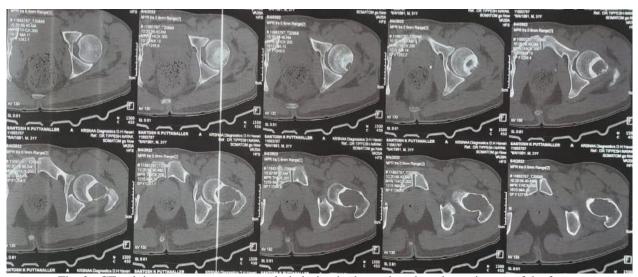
CT pelvis scan suggests an osteolytic lesion in the neck and trochanteric area of the femur
